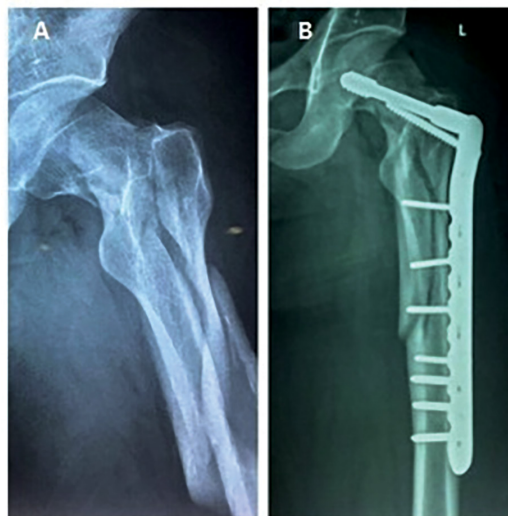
Pre-op & Post-Op x-rays of 37 Years Male (A, B).
